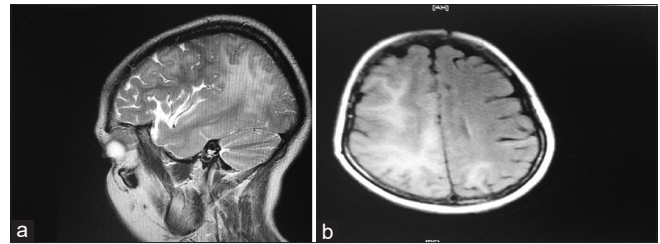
A 47-year-old woman presented with subacute onset progressive weakness of the left upper limb followed by lower limb with visual impairment in the left eye and dysarthria over a period of 4 weeks duration. Magnetic resonance imaging brain shows diffuse bilateral asymmetrical altered signal intensity lesions in the subcortical (arcuate U-fibers) and deep white matter in the right Fronto-parieto-temporal region and left occipital lobe, midbrain superior colliculus, and cerebral peduncles. Lesions were hyperintense on T2 and fluid-attenuated inversion recovery and hypointense on T1 with no mass effect or contrast enhancement. (a) MRI Brain Sagittal section T2 weighted image (b) MRI Brain Axial section T2 weighted image
